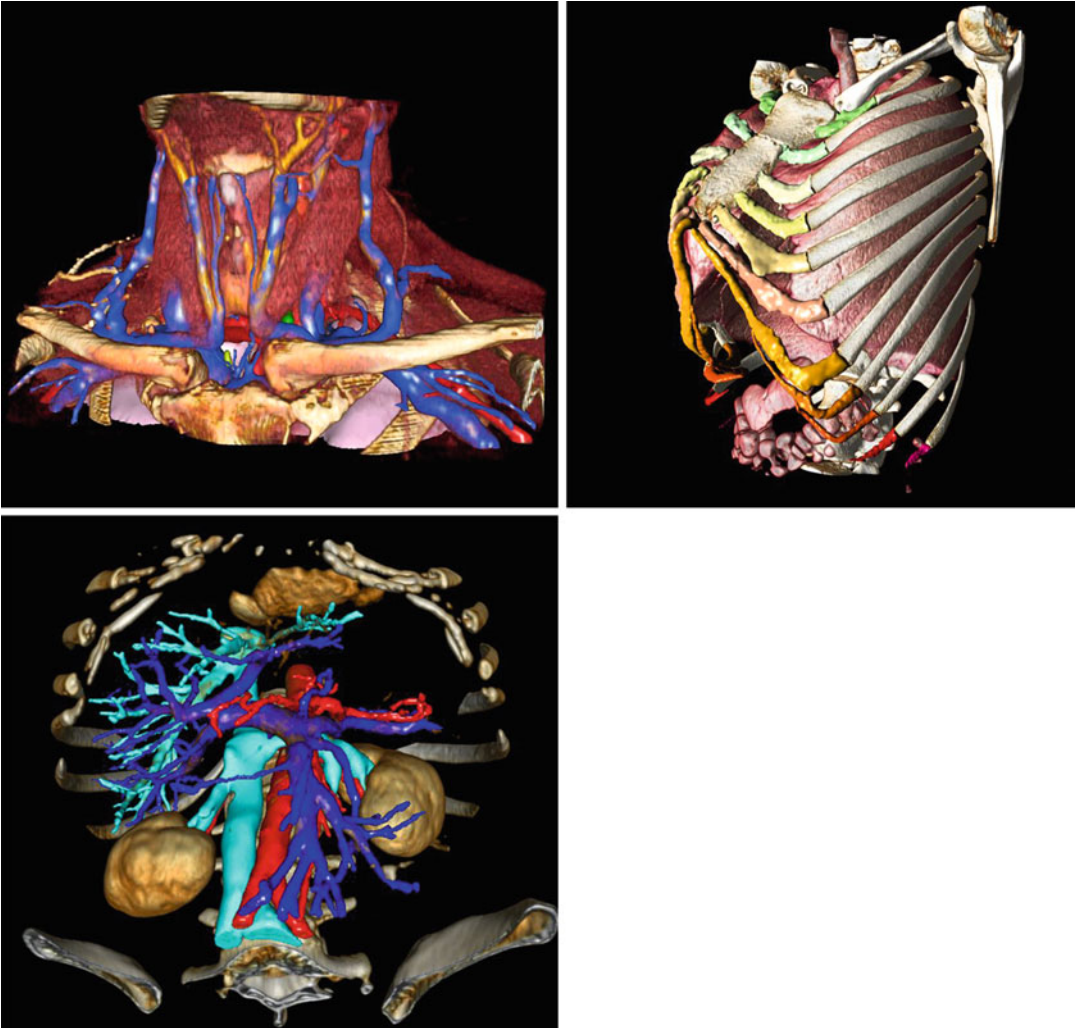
Direct volume rendering of three different clinical cases from their DICOM image, here CT scan of the neck (a), thorax (b), and abdomen (c)
